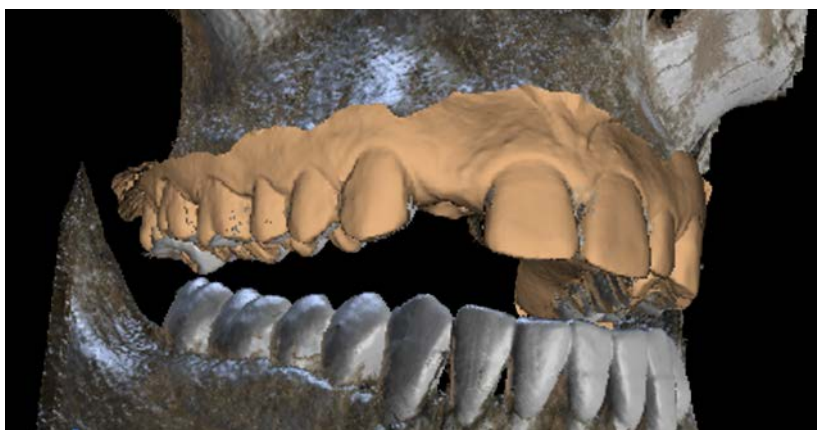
Combining CBCT and intraoral optical scan data facilitates detailed, accurate presurgical planning.
